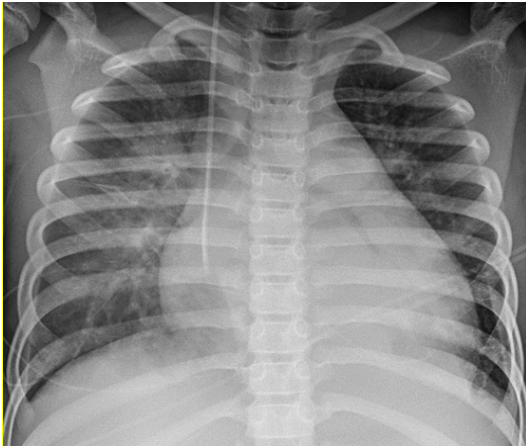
7-year-old male, with MIS-C associated with COVID-19, who presented with symptoms of fever, sore throat vomiting, abdominal pain, truncal rash, and hypotension. Frontal chest radiograph shows cardiomegaly, pulmonary edema, and small bilateral pleural effusions¹⁵⁷ Printed with Permission
